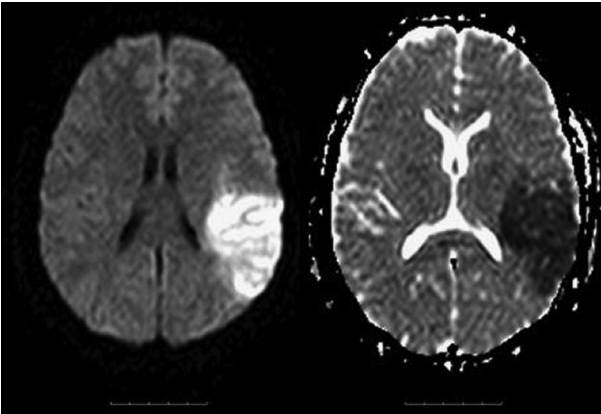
DWI MRI in acute stroke. The left picture shows the DWI image of a slice through a left frontoparietal ischaemic infarct. It can be seen as high signal (white) on the DWI image. On the ADC map (right), the acute infarct is seen as a corresponding area of low signal. © Anthony Pereira.
